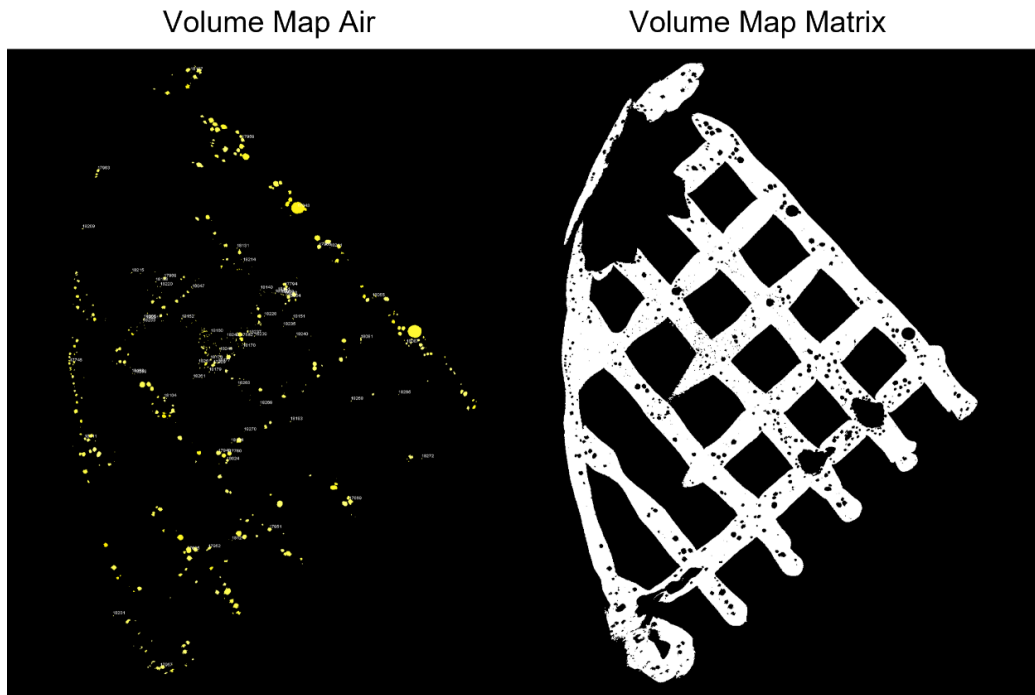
Exemplary images of volume maps of inserts obtained during image analysis of  $\mu$ CT images.
